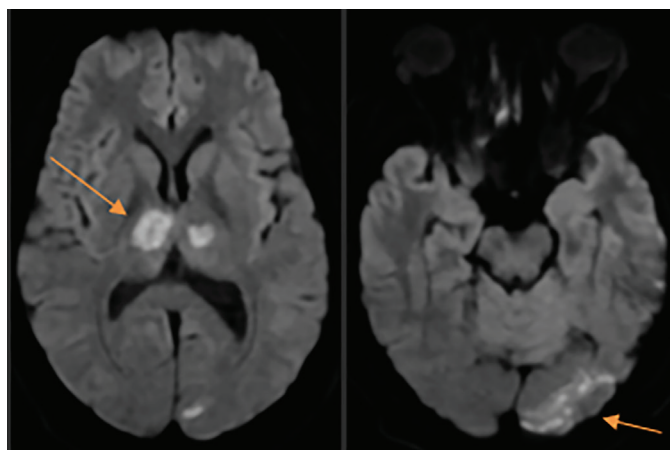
Axial DWI images showing restricted diffusion in bilateral thalami and the left occipital lobe reflecting the cytotoxic edema secondary to an acute infarction (arrows)
